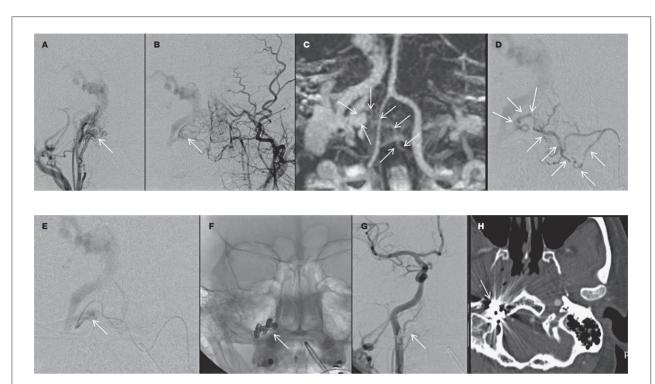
Case 11. A patient had pulsatile tinnitus for 2 years and right proptosis recently. Diagnostic angiographies of the external carotid on the right (A) and left (B) show a dural arteriovenous fistula (DAVF) (arrow) in the right anterior condylar veins. The inferior petrosal sinus was occluded in below. Retrograde flow to the cavernous sinus and superior ophthalmic vein are noted. Maximal intensity projection view (C) of CT angiogram shows a prominent artery (arrows) from the left side communicating to the venous sac which is confirmed on the superselective angiogram (D) at the clival branch of the left ascending pharyngeal artery (arrows). Embolization was performed with a microcatheter navigating into the venous sac (E) and coil packing (F, arrow). Immediate post-procedure angiogram (G) shows the complete obliteration of the fistula (arrow) and follow-up CT scan shows the coil mass in the hypoglossal canal and anterior condylar confluence (arrow).
